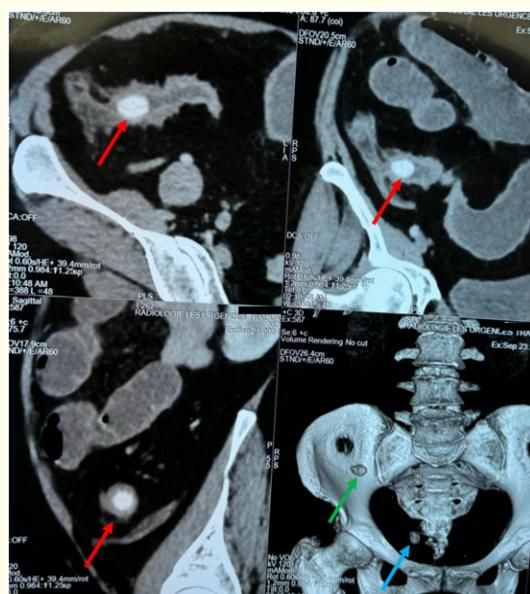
CT scan showing a foreign body completely obstructing the intestinal lumen, with upstream small-bowel dilation (red arrow). The 3D reconstruction demonstrates one foreign body projected toward the right iliac fossa (green arrow) and a second one located in the pelvic region (blue arrow).
